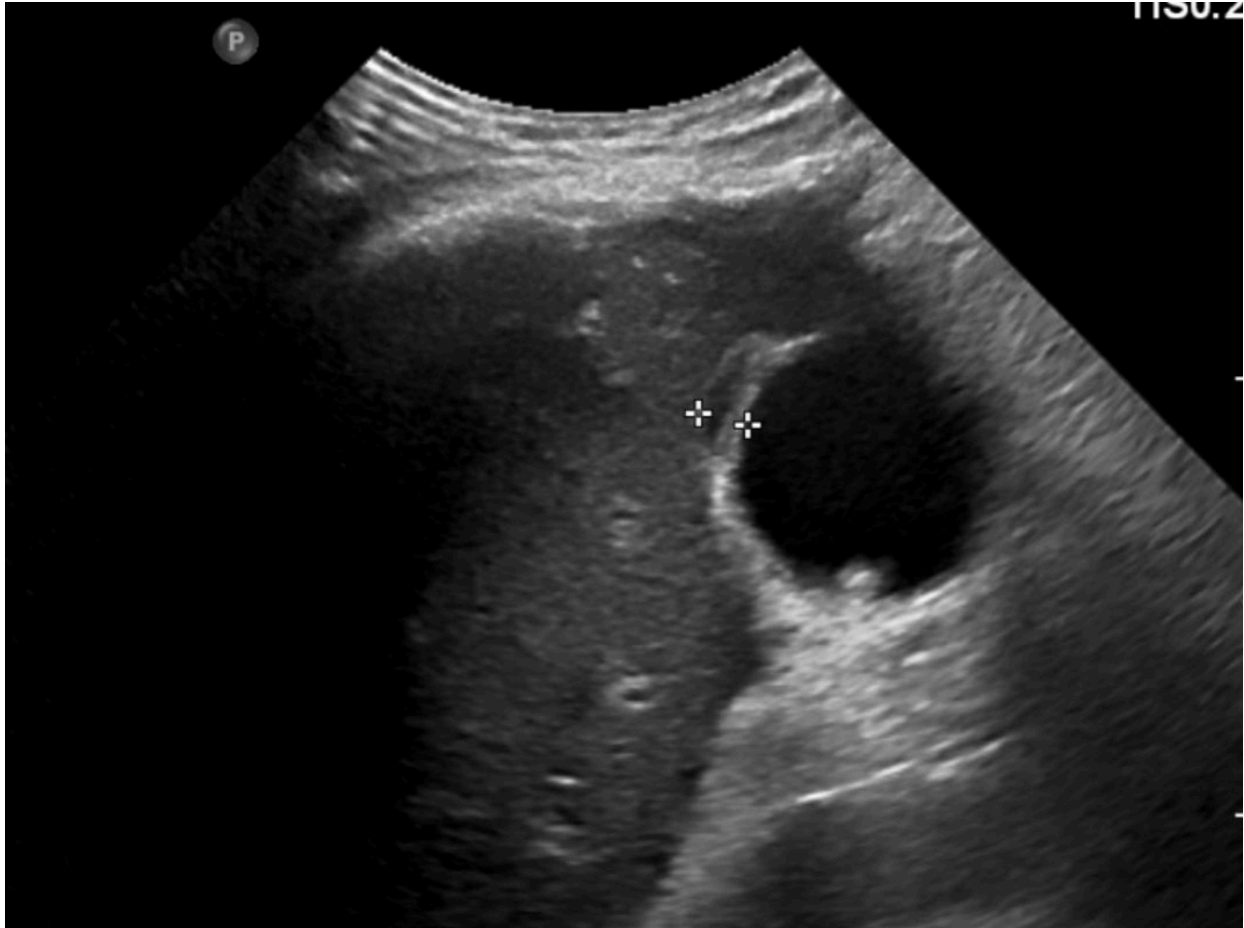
Ultrasound abdomen: Gallbladder: Gallbladder wall thickening noted, measuring 6.3 mm, with associated edema and trace pericholecystic fluid. A 5.5 mm non-mobile, hyperechoic, non-shadowing lesion is seen within the gallbladder. Common bile duct: Not dilated, measuring 3 mm. (No intra-abdominal collection. Oedematose thick gallbladder wall might indicate cholecystitis.)
